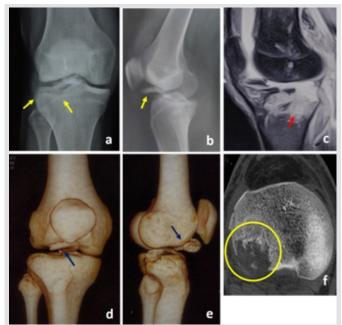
Pre-operative Imaging of Case 1: (a and b) The posterolateral tibial condyle shear fracture in seen on plain radiographs (yellow arrows in anteroposterior and lateral views). (c) Magnetic resonance imaging scan proton-density fat-saturated sagittal section shows extensive bone marrow edema (red arrow) in the posterolateral tibia. (d and e) 3-D reconstruction of CT scan shows the osteochondral fragmentlying anteriorly in the region of fat pad and flipped so that the articular surface is facing inferiorly (blue arrow). (f) Axial section of CT scan through the tibia articular surface shows loss of bone from the posterolateral margin (yellow circle).
